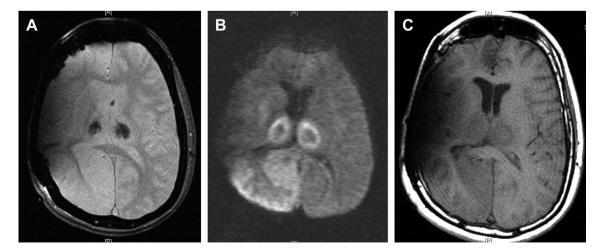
(A) Magnetic resonance (MR) imaging study on T2 weighted gradient—echo images showing marked hypointensity on both sides of the thalamus. (B) Diffusion-weighted MR image revealing a lack of diffusion restriction within both sides of the thalamus and right occipital lobe. (C) Axial images, T1-weighted image, showing hypointensity lesion in the thalamus bilaterally, and in the right parieto-occipital lobe.
